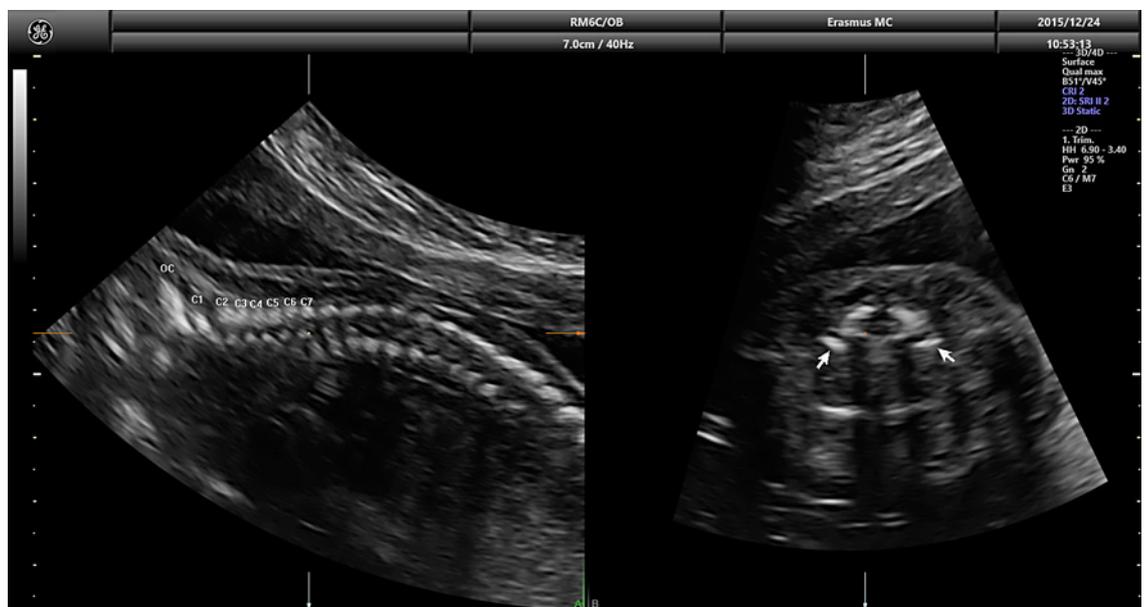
Sagittal and transverse ultrasound view of the vertebral column. In 4DView, the transverse view at the level of the seventh cervical vertebral column can be visualized simultaneously, corresponding with the yellow dot in the sagittal view. The arrows point to the bone-white structures that were classified as bilateral rudimentary cervical ribs. OC, occiput; C1, first cervical vertebra; C2, second cervical vertebra.
